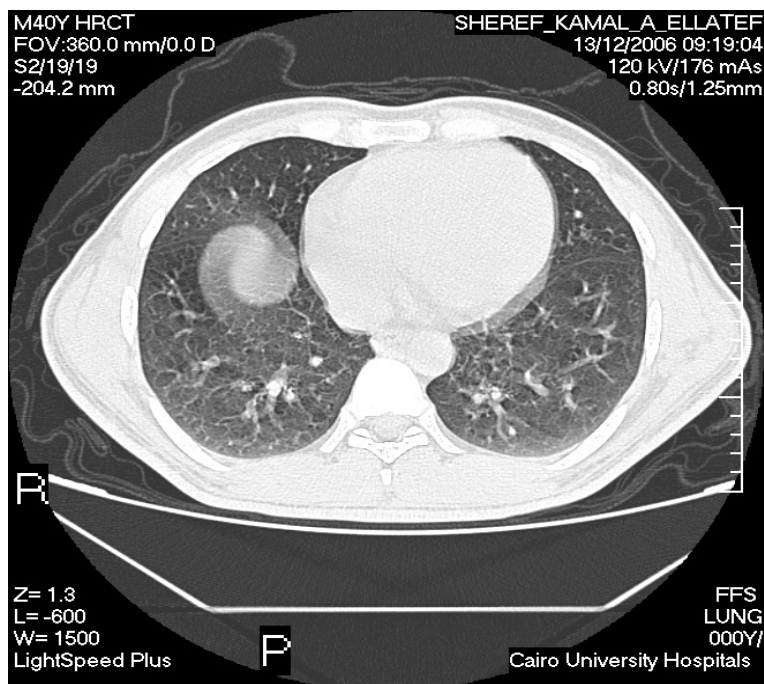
HRCT chest of case (no.30) A 40 year old male patient with HCV infection, non smoker. He had no chest complaint. This cut of HRCT revealed bilateral lower lobe groundglass attenuation. The rest of the cuts showed left basal (lateral) cysts. He took a score of 4.
